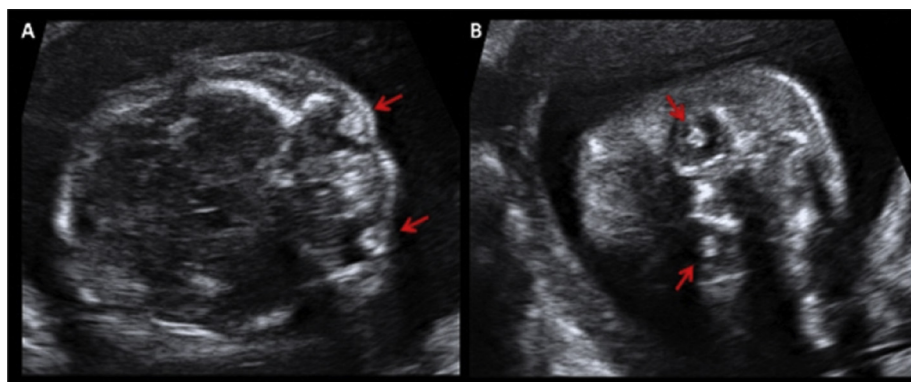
Two-dimensional prenatal ultrasound images. Bilateral dense echogenic lenses are indicated by arrows. (A) Transverse view. (B) Coronal view.
